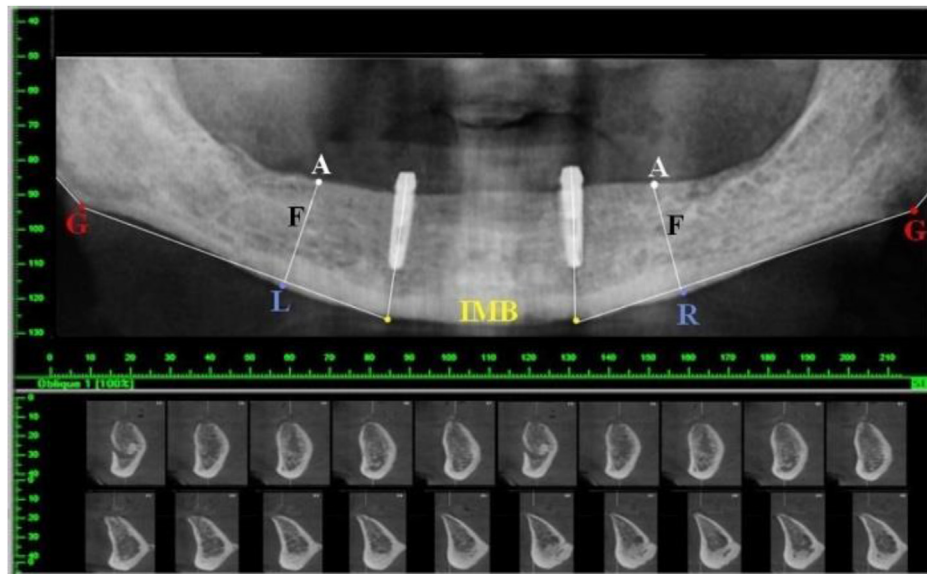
A photograph showing traced panoramic image of CBCT Scan of the mandible.
